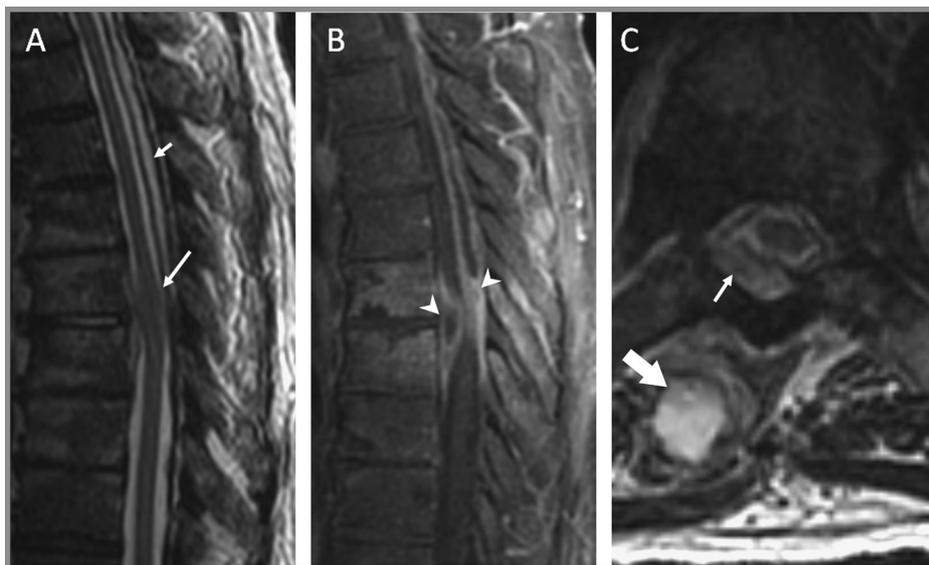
Epidural abscess. Sagittal (A) and axial (C) T2-weighted and sagittal T1-weighted (B) MRI with contrast of the thoracic and lumbar spine demonstrate focal T2 changes in the bone and disk that vividly enhance, consistent with osteomyelitis. B, Focus of enhancing fluid collection (arrowheads) surrounding the cord and exerting mass effect (thin arrow in panel C). The posterior fluid collection demonstrates significant cephalic extension. C, A large enhancing mass within the paraspinal muscle consistent with an abscess (thick arrow).
